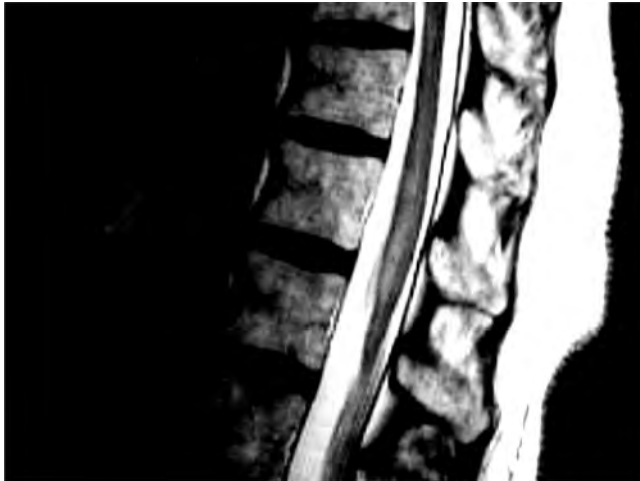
Spinal cord infarction. A 60-year-old woman presented with sudden radicular low back pain radiating around the umbilicus with sudden leg weakness and numbness. This progressed over several hours with loss of sphincter function. T2 coronal MRI shows abnormal high signal in the central portion of the lower dorsal cord.
